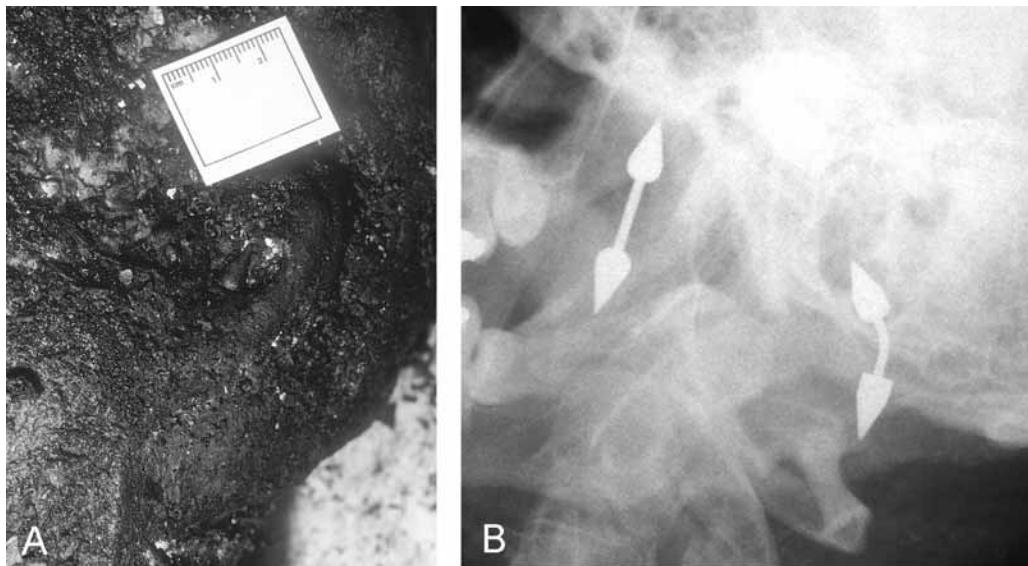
Charred body. Motor vehicle collision and fire. Identification by personal effects. (A) Left ear. Earring not seen because of charring. (B) Radiograph shows distinctive earrings.
